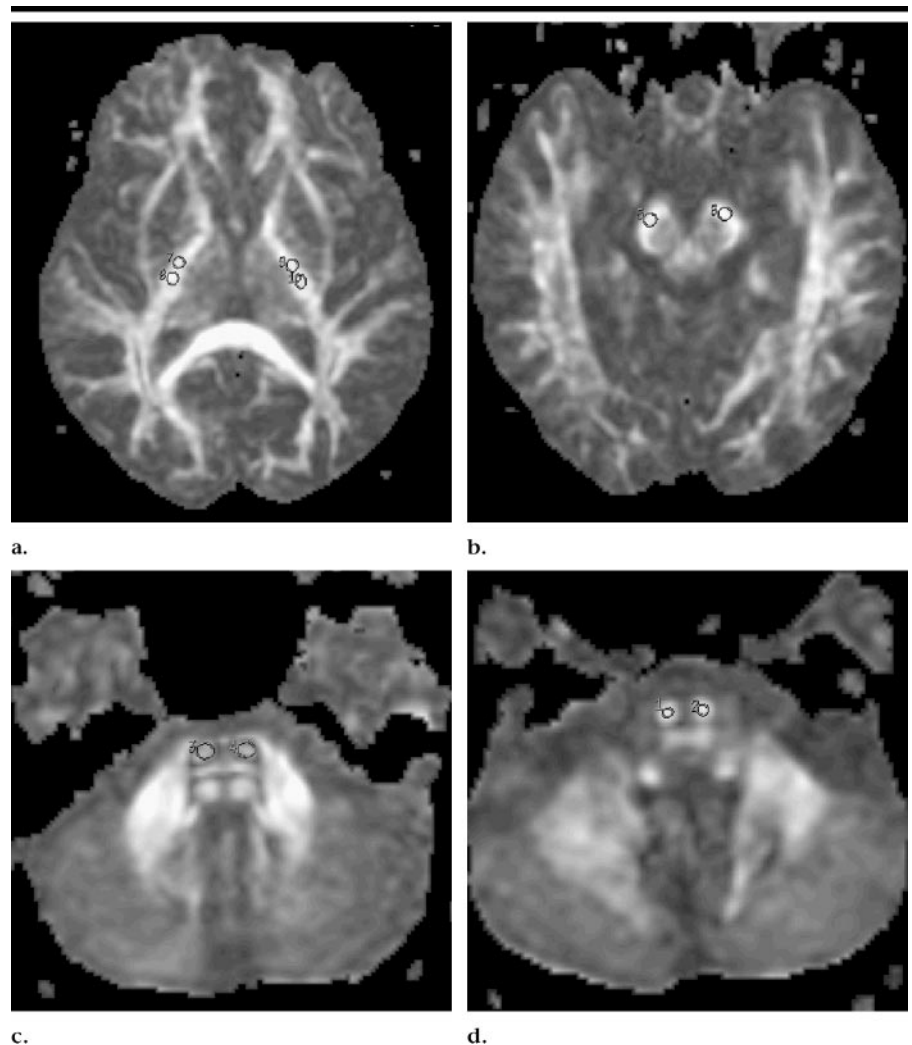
FA maps acquired at different levels along corticospinal tracts. FA maps were calculated after the acquisition of 25 spin-echo echo-planar imaging diffusion-weighted MR images (6500/79.9; field of view, 24 × 24 cm; section thickness, 5 mm; intersection gap, 1 mm; matrix, 128 × 128; number of signals acquired, two; $b = 1000$ sec/mm²) along noncollinear directions and a reference image without diffusion weighting. For each patient and control subject, two ROIs were placed in (a) both internal capsules, (c) pons, and (d) pyramids. Single mean FA, MD, λ_1 , λ_2 , and λ_3 values were estimated from the averaged values of the diffusion-tensor imaging parameters in the 10 ROIs.
